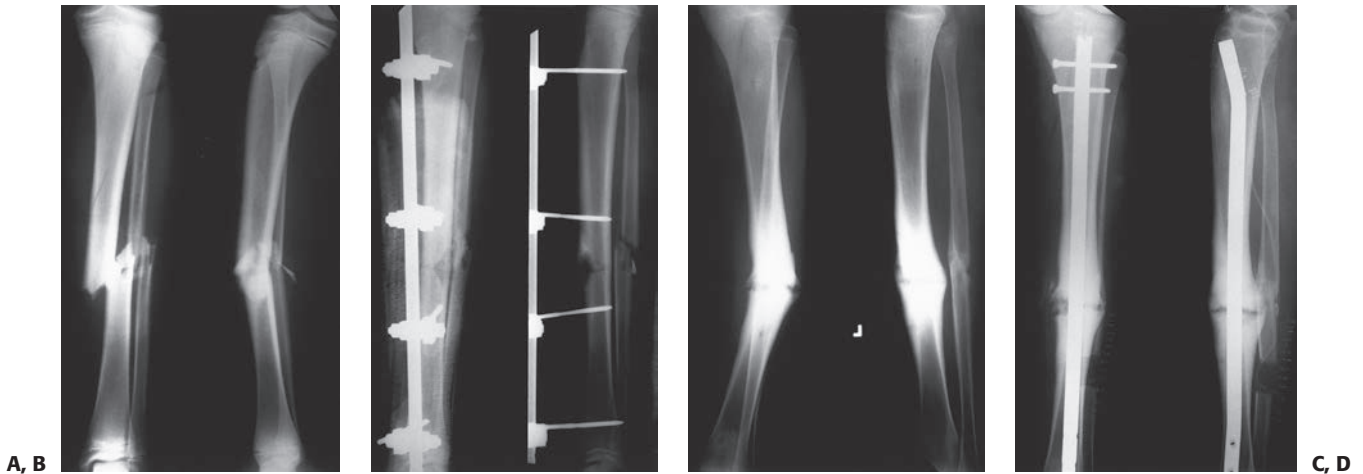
A: Anteroposterior and lateral radiographs of a 14-year-old adolescent who was struck by a car, sustaining a grade IIIB open fracture of the tibia. B: Anteroposterior and lateral radiographs of the tibia after irrigation and débridement, and application of an external fixation device. C: The patient developed a nonunion at the tibia, which progressively deformed into an unacceptable varus alignment. D: The nonunion was treated with a fibular osteotomy followed by a closed angular correction of the deformity and internal fixation with a reamed intramedullary nail.
